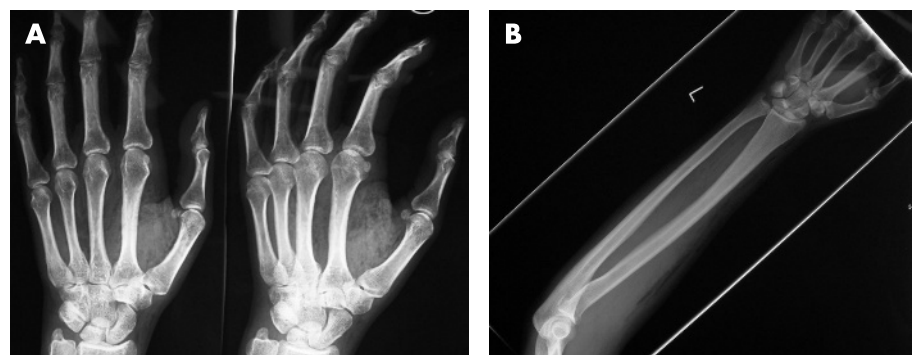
(A) Anteroposterior (AP) and oblique radiograph of the left hand in case 1 showing gas in the subcutaneous tissues. (B) AP radiograph of the left hand and forearm in case 2 showing gas in the subcutaneous tissues.
